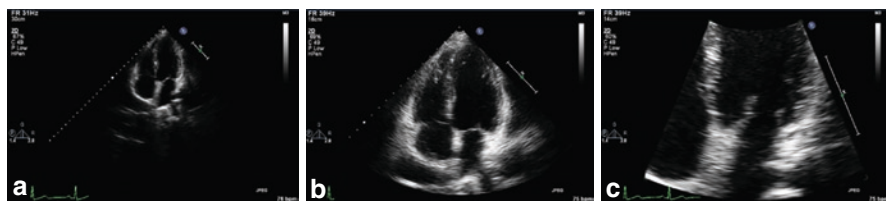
Image optimization – depth and zoom controls. The image depth and zoom controls can be used to optimize the area of interest. In these examples (a) the depth is set too deep resulting in a small image that will be difficult to assess, (b) the depth is set at the correct level so that all structures can be seen in the apical 4C view, and (c) the use of the “zoom” control for better assessment of the mitral valve
